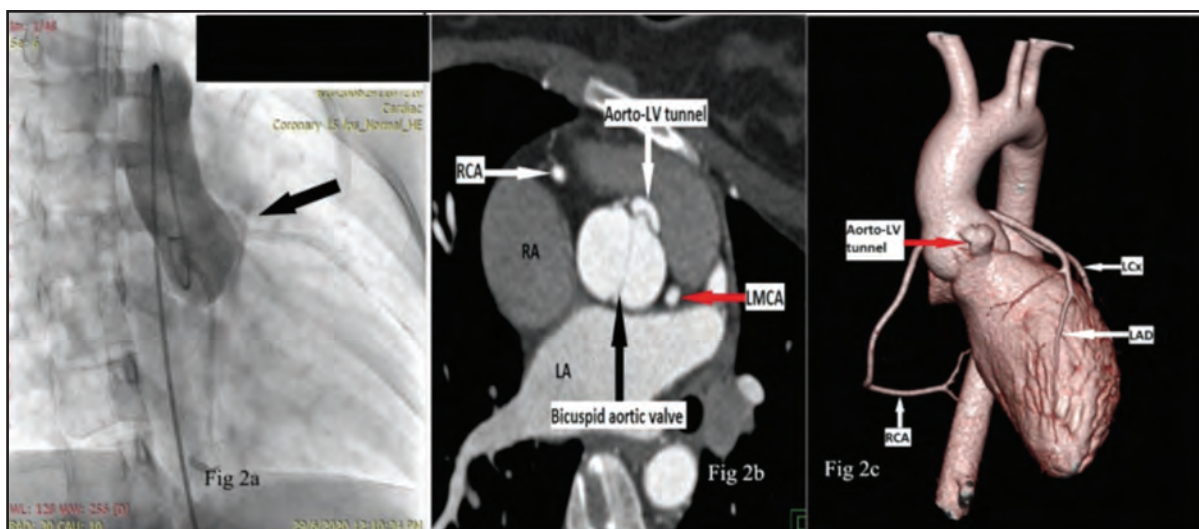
An angiogram of the patient from the RAO 30o view (Fig 2a) revealing the left AVT (arrow). The top right corner was blacked out to remove the patient’s details. AVT=aorto-ventricular tunnel. RAO (right anterior oblique) CT angiogram of the patient at the level of the aortic valve (Fig 2b). Left AVT is labelled (fine arrow). Reconstructed 3D CT image (Fig 2c) showing mainly the left ventricle, aorta and coronary vessels and left AVT (labelled). LA=left atrium, LAD=left anterior descending artery, LCX=left circumflex artery, LMCA=left main coronary artery, RA=right atrium, RCA=right coronary artery.
